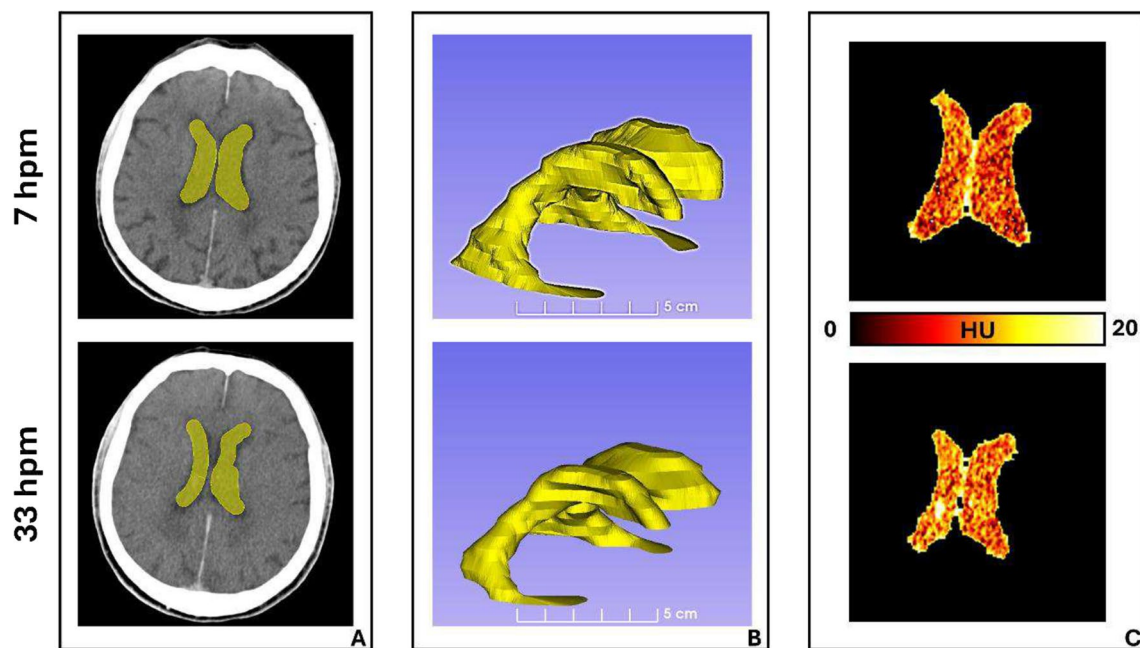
Lateral cerebral ventricles (LCVs) segmentation and post-mortem changes. We report the segmentation and visualization of the LCVs at two different postmortem time points for a representative subject. The presented scans have been acquired at about 7- and 33-hours postmortem (hpm). A shows an axial section of the two CT images with the corresponding segmentations of the LCVs overlaid
